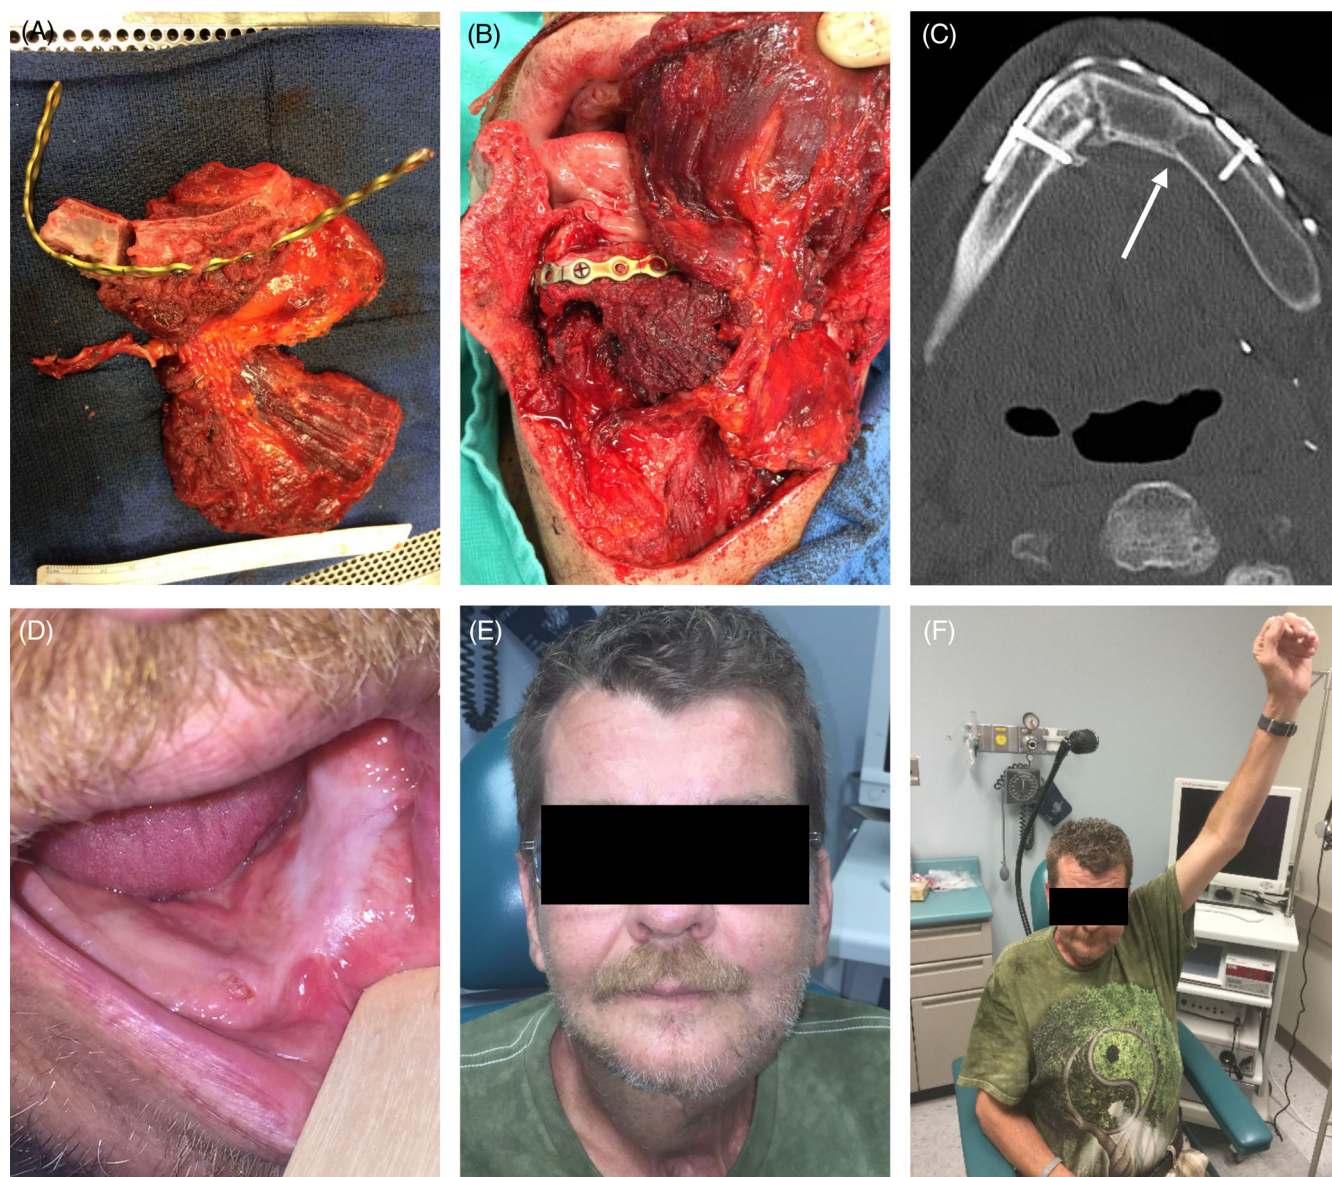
(A) Single osteotomy scapula. (B) Latissimus muscle for intraoral component. (C) Postoperative CT, scapula (image-right) mirrors native mandible, arrow at union. (D) One-year later, intraoral muscle re-mucosalized, (E) Edema resolved, and (F) Full shoulder ROM.
